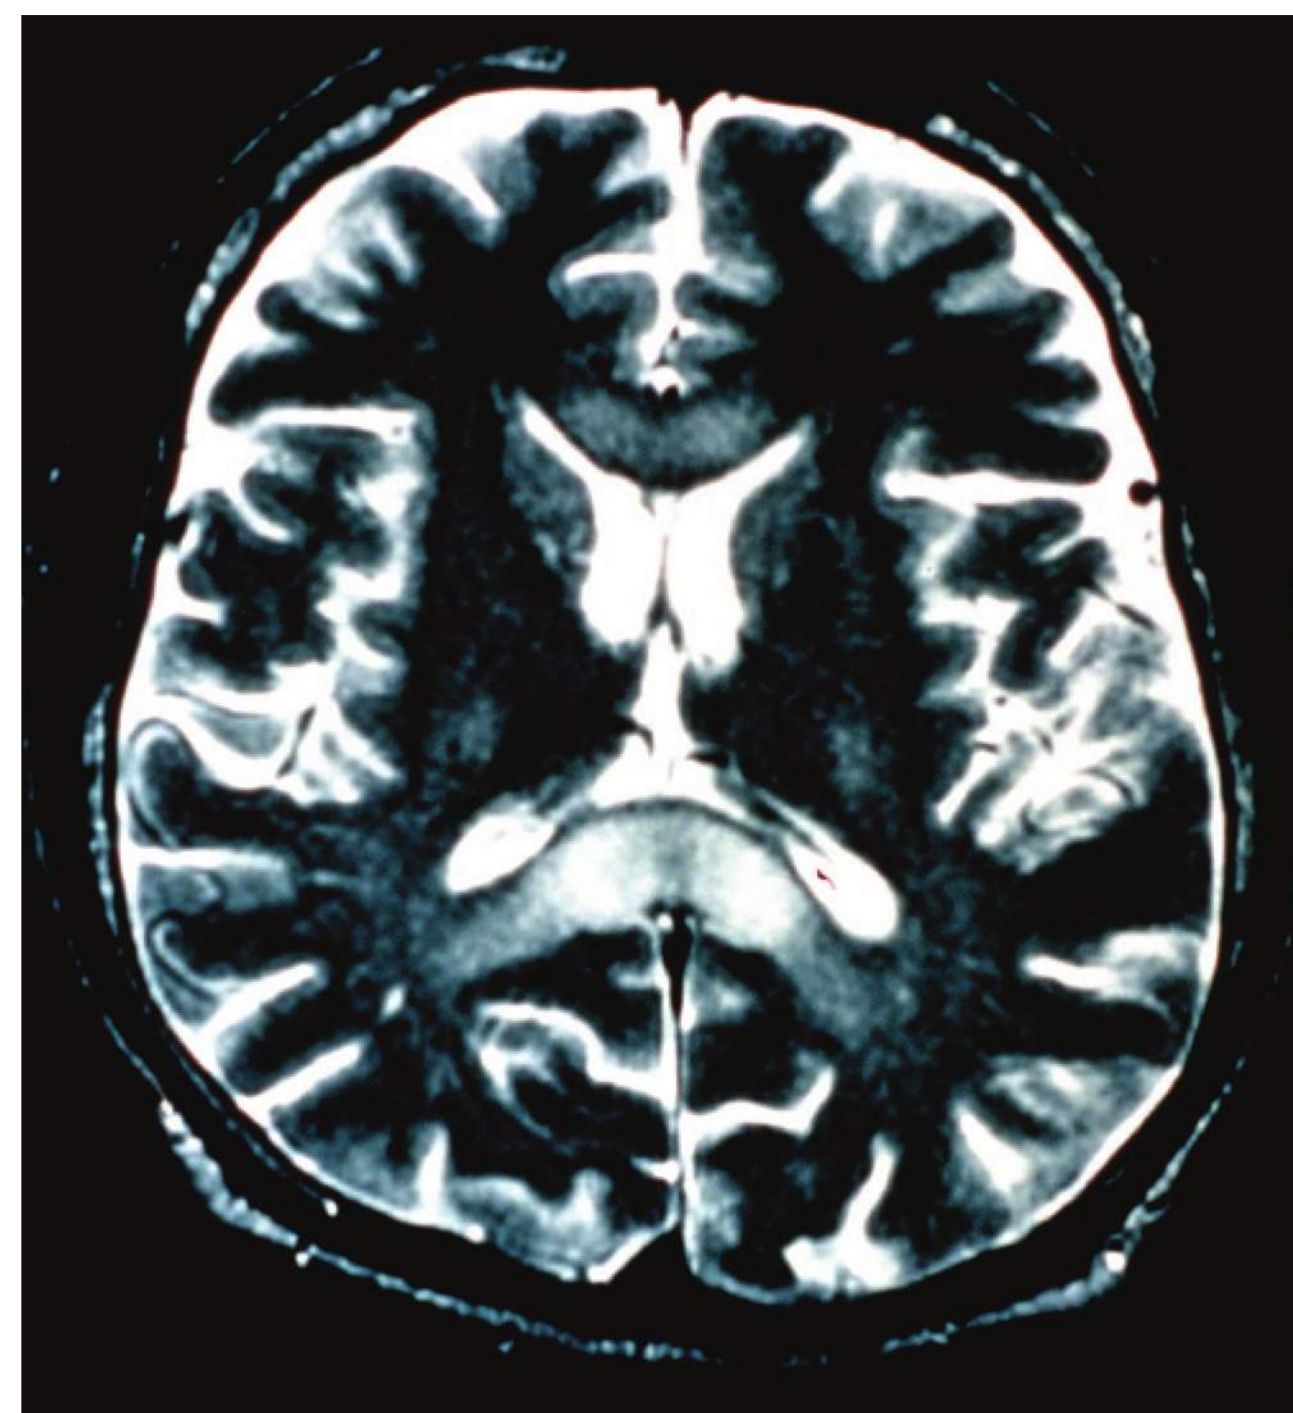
■ MRI Brain—HACE. MRI of a patient with high-altitude cerebral edema. Note the increased white matter signal, especially in the splenium of the corpus callosum, in this T2-weighted image. (Photo contributor: Ken Zafren, MD.)
